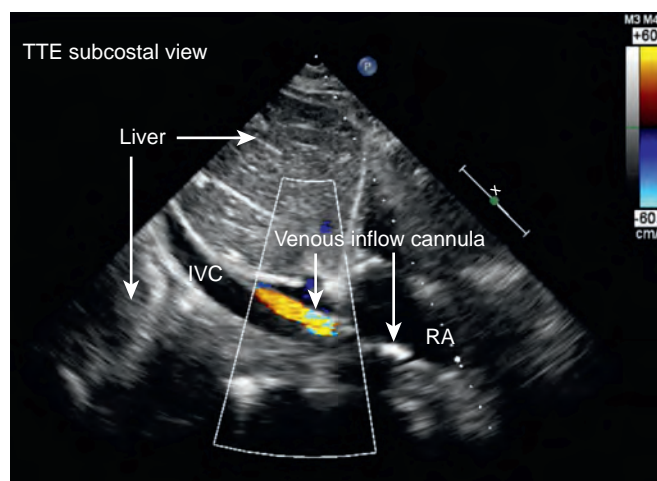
Transthoracic echocardiographic (TTE) image of venoarterial (VA) extracorporeal membrane oxygenation (ECMO) inflow cannula within the inferior vena cava (IVC) and right atrium (RA). In the subcostal TTE view, the "venous" inflow cannula for a patient undergoing peripheral VA ECMO is visible within the IVC and RA. Fenestrations within the cannula are marked by white arrows. In a patient with relative or absolute contraindication(s) to transesophageal echocardiography, TTE is warranted and may provide clear and diagnostic imaging for ECMO cannula placement. (Courtesy K. Ghadimi, MD.)
